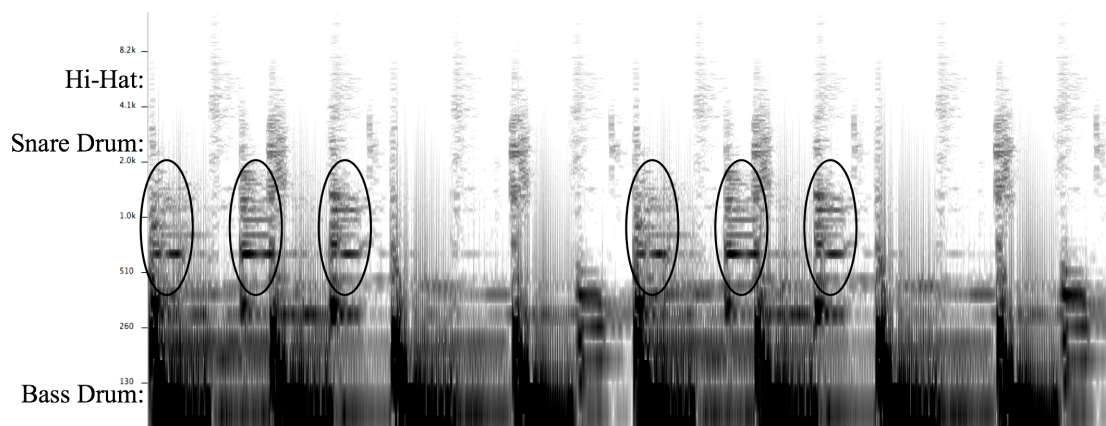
Sonogram of Lee-Cabrera’s *Shake It*, 0:00–0:04, with the standard pattern circled.
